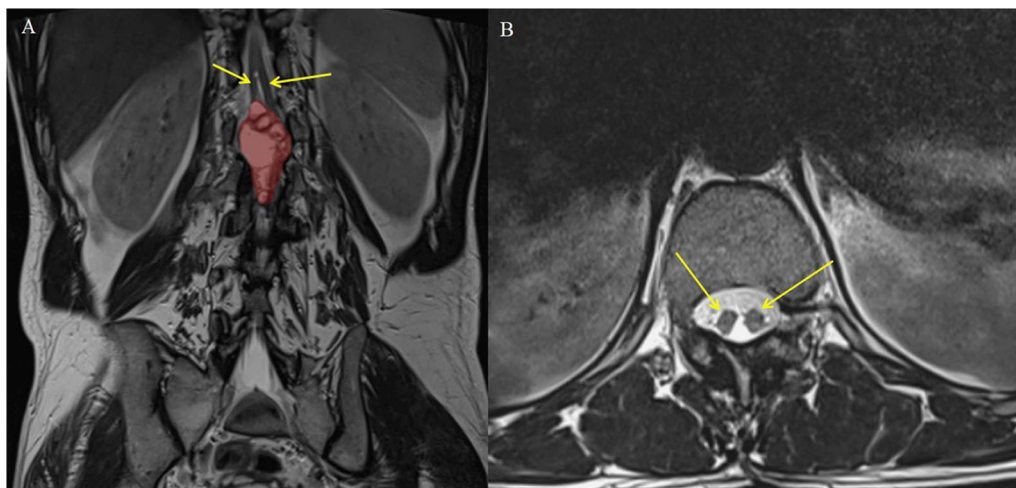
T2-weighted sequences showing a dermoid cyst in the cauda equina associated with a split cord. A Coronal sequence demonstrating a ceriths-like mass of the cauda equina (red surface) located just below a split medullar cord (yellow arrow). B Axial sequence showing the diastematomyelic spinal cord (yellow arrow) within the same dural sac, without evidence of an osseous spur
